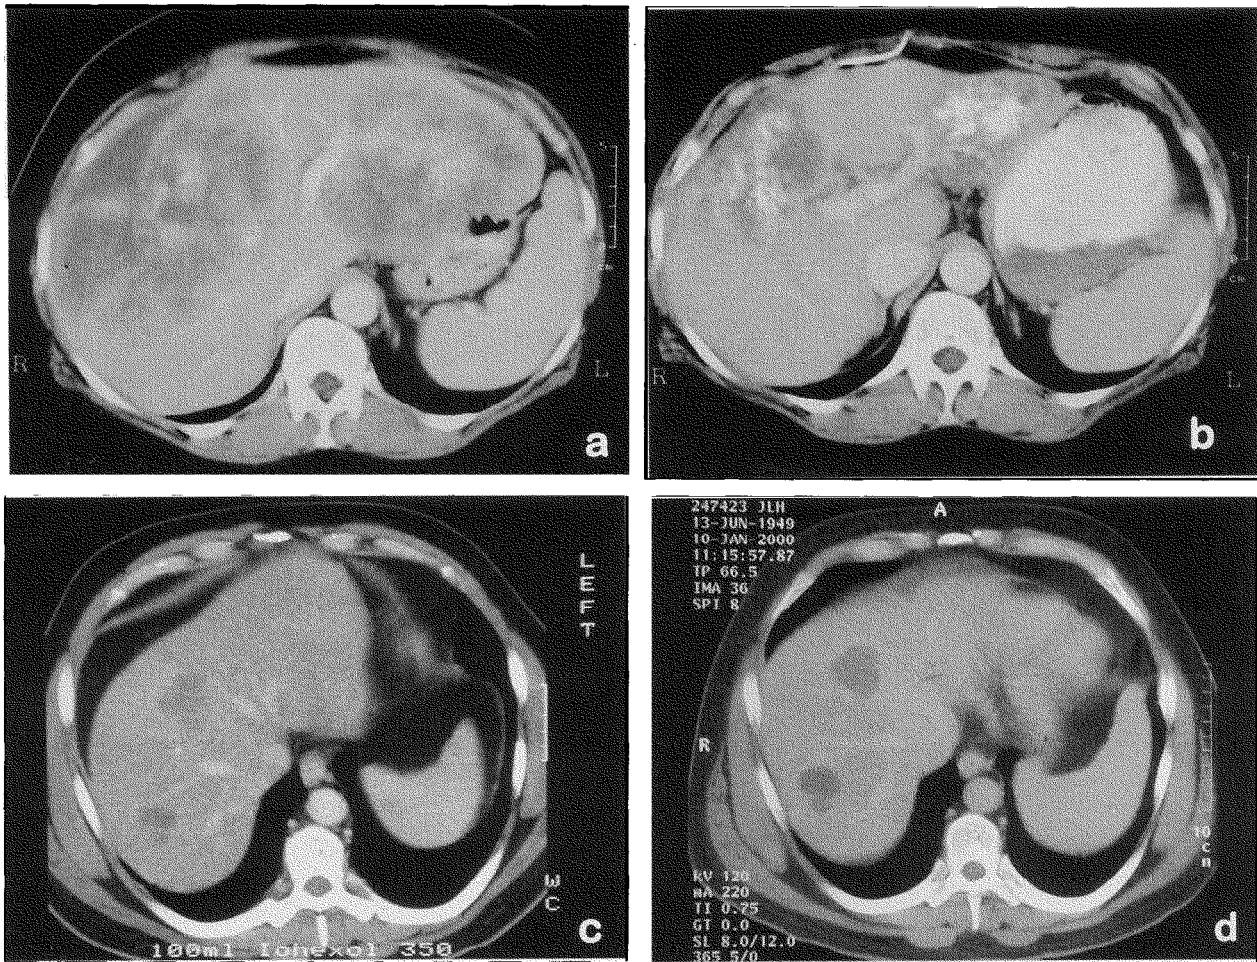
CT changes after SIRT in two patients who responded well to treatment. A and B, Two large liver metastases before and 6 months after SIRT. Corresponding CEA values were 23,160 ng/ml and 2312 ng/ml, respectively. C and D, Two metastases in another patient before and 6 months after SIRT with no significant change in size but a decrease in CEA from 11.1 ng/ml to 1.2 ng/ml.
